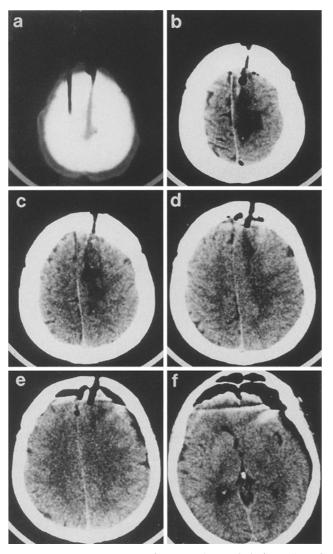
Axial CT-scans of the head on admission. Note the asymmetry of the cerebral hemispheres with falx and superior sagittal sinus lying more to the left side. Bifrontal pneumatocele indicates the dural lesion; the injured right hemisphere is oedematous and swollen. The hesitation injury can be seen on the left side
